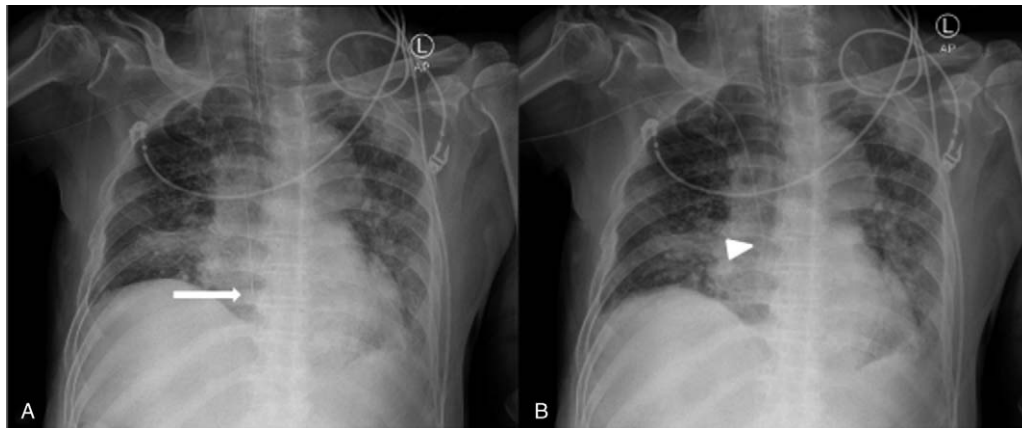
A 69-year-old man with lobar pneumonia: (A) portable chest X-ray image with a fixed guidewire length of 40 cm, and (B) portable chest X-ray image after correcting the length and inserting catheter. The tip of the catheter (arrowhead) is positioned at the cavoatrial junction correctly compared with the tip of the guidewire (arrow).
